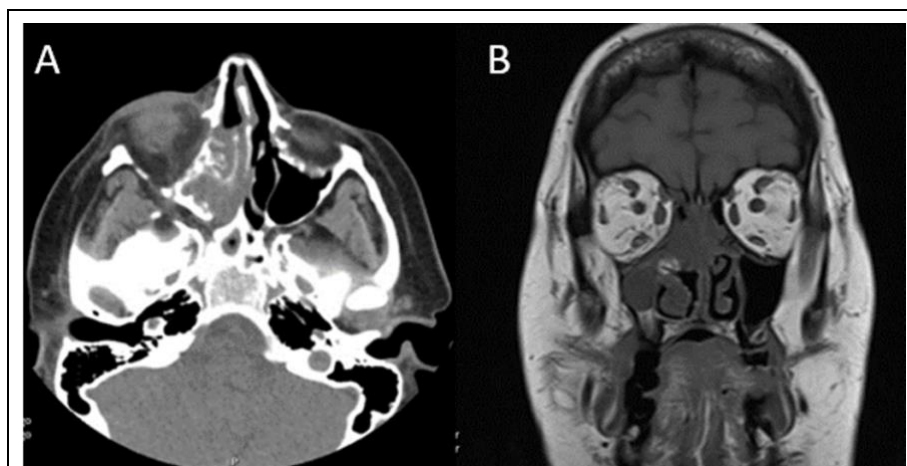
Initial Imaging: (A): Axial and coronal; (B): Magnetic Resonance Imaging (MRI) slice demonstrating opacification of ethmoid air cells, which, in the context of poorly controlled diabetes, was concerning for fungal angioinvasion.
